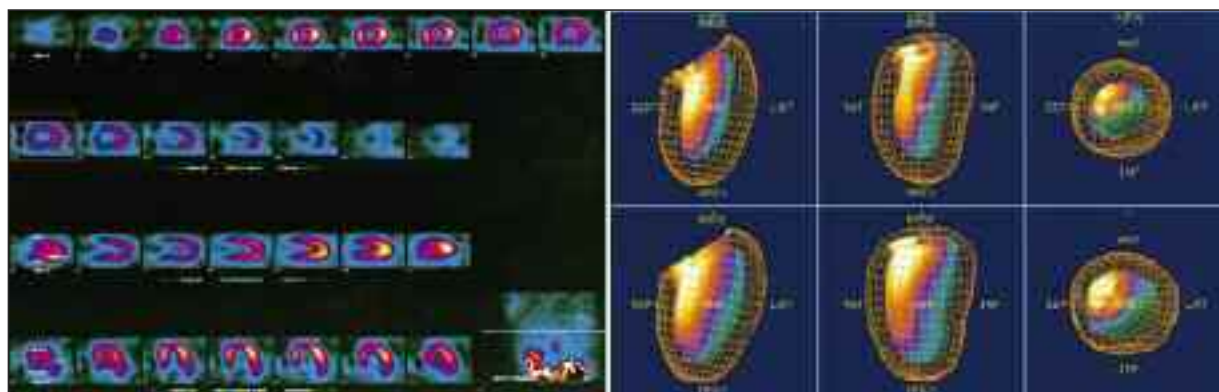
Resting myocardial perfusion SPECT showing a perfusion defect of the anterior and inferior-lateral of the left ventricle.
